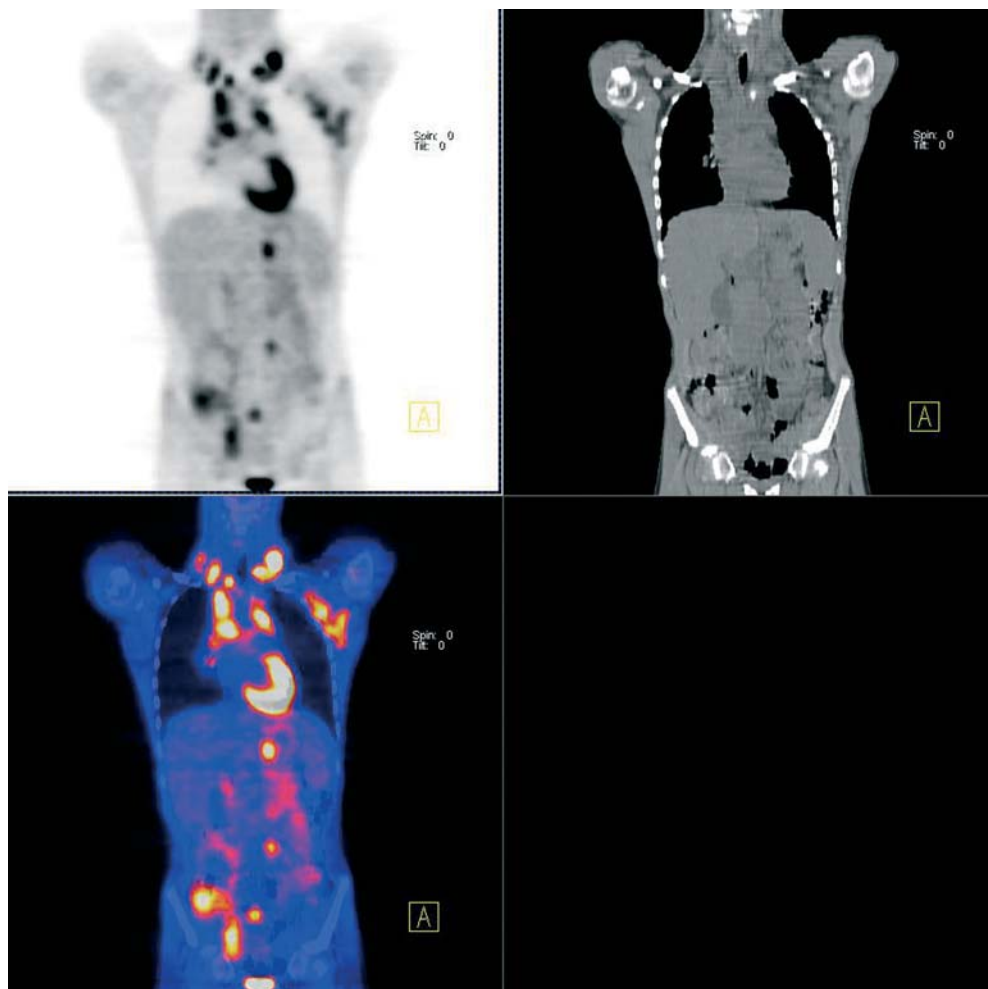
Coronal images of FDG-PET/CT of 11-year-old child with newly diagnosed nodular sclerosing Hodgkins disease following left axillary lymph node biopsy. *Upper left panel:* FDG-PET scan shows increased uptake of FDG in bilaterally in the lower neck and mediastinum, the left axilla, the right hilum, the left mid- and lower abdomen, and centrally within the pelvis. *Upper right panel:* CT image corresponding with FDG-PET scan. *Lower left panel:* Fusion image of these FDG-PET and CT images.
